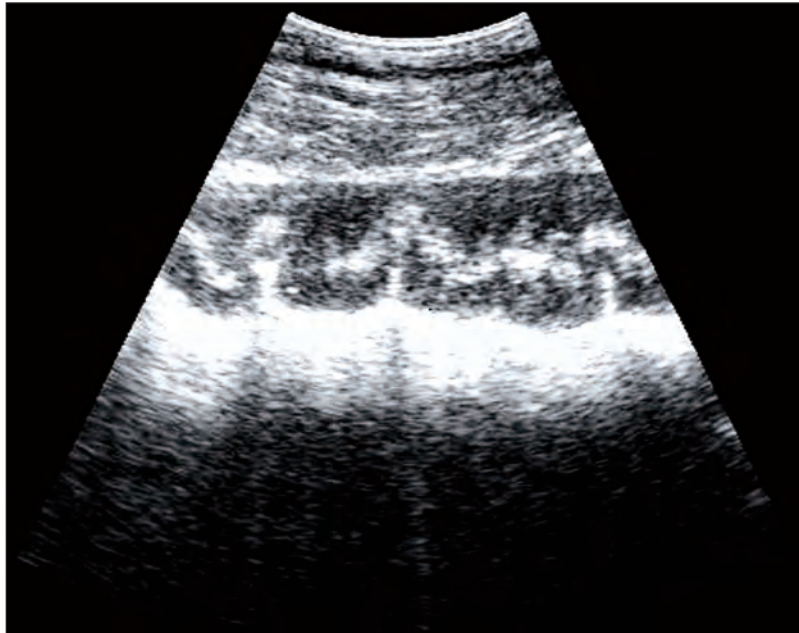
Ultrasonographic image of the left ventral colon in a 7-year-old Andalusian mare evaluated for diarrhea, signs of abdominal pain, anorexia, and lethargy of 5 days' duration.
